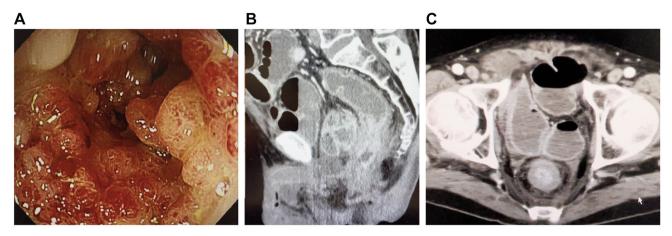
Colonoscopy and computed tomography findings prior to pembrolizumab treatment. Colonoscopy showing a granular prominence a few centimetres from the anal verge and a stenosis (A). Sagittal (B) and transverse (C) computed tomography showing circumferential thickening of the rectal wall.
